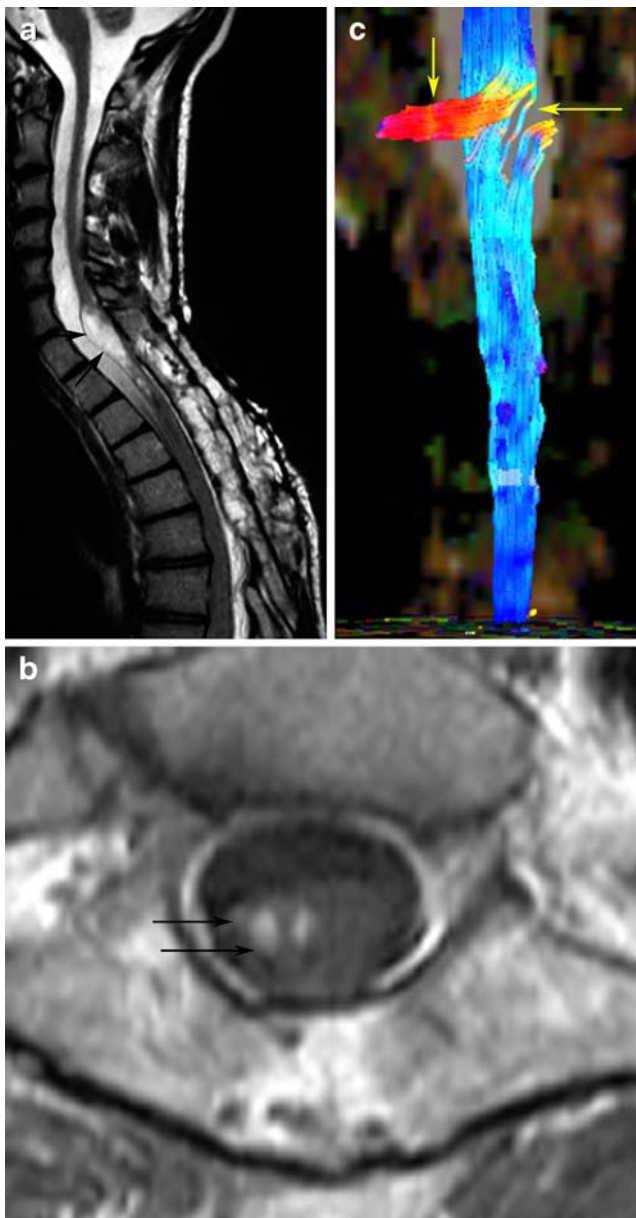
Pilocytic astrocytoma. a The sagittal T2-weighted image shows an expansive lesion in the spinal cord (*arrows*). b There is some enhancement on the right side in the cord (*arrows*). c The tractogram shows that the fibres have an altered course, probably due to a previous operation (*arrows*)
